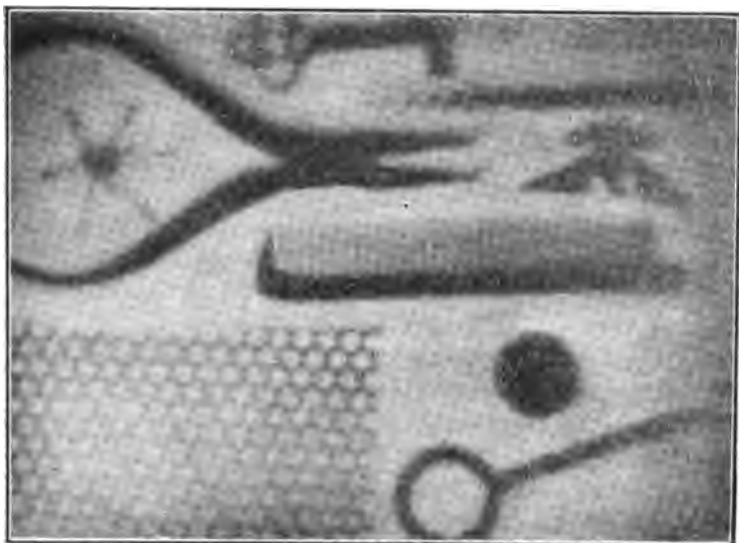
Radiograph taken with 10 milligrams of radium; radioactivity, 300,000; distance from plate, 3 inches; time of exposure, 18 hours. Stanley plate used and *inserted inside* of plate-holder, upon which rested the objects here pictured.
